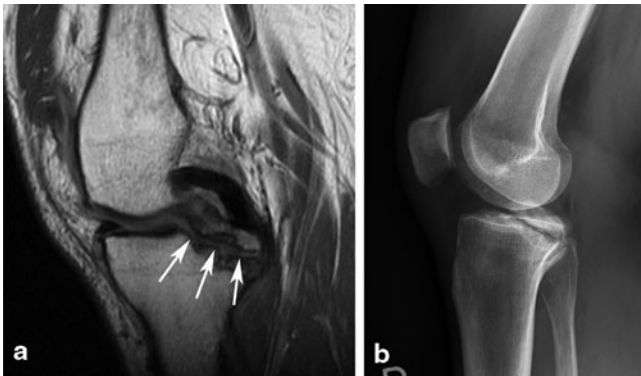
Osseous avulsion of PCL. a Nonfat-suppressed PD images show intact PCL with osseous avulsion of PCL at tibial attachment (arrows). b Corresponding X-ray shows osseous avulsion as well. Note hypointense fracture margins on MRI and sclerotic fracture margins on X-ray, consistent with chronic rather than acute injury. PCL posterior cruciate ligament, PD proton density, MRI magnetic resonance imaging
